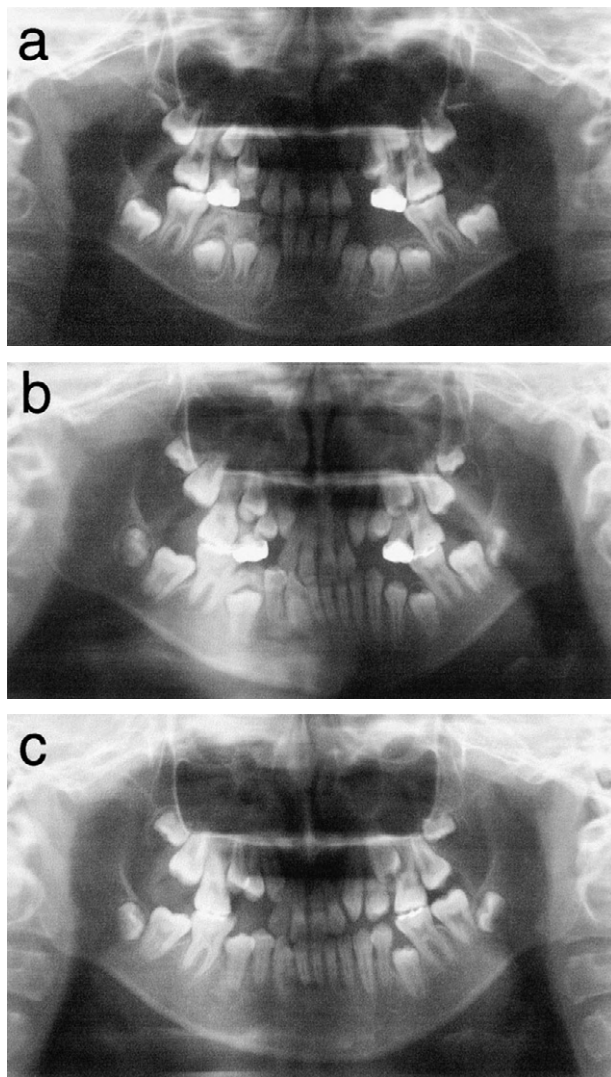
Orthopantomographs images taken at 10Y2M (a), 13Y1M (b), and 14Y5M (c)
